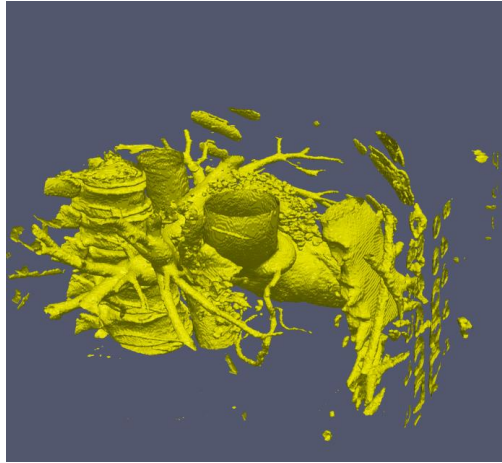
CTA volume data segmentation.
